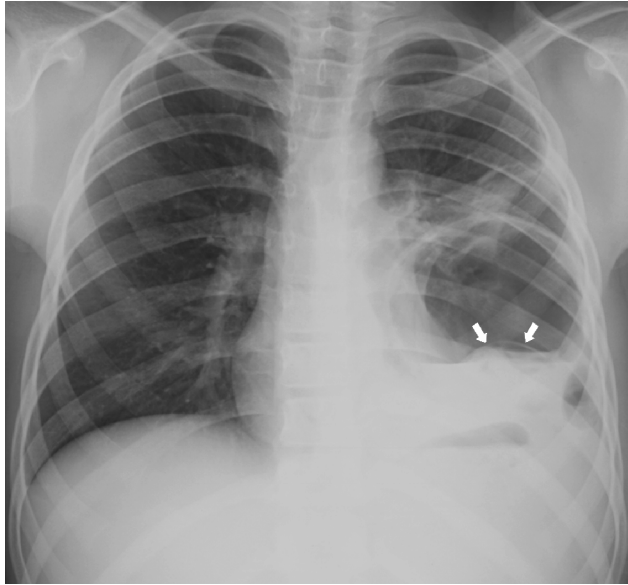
Chest radiograph revealing a ruptured hydatid cyst with an air–fluid level
